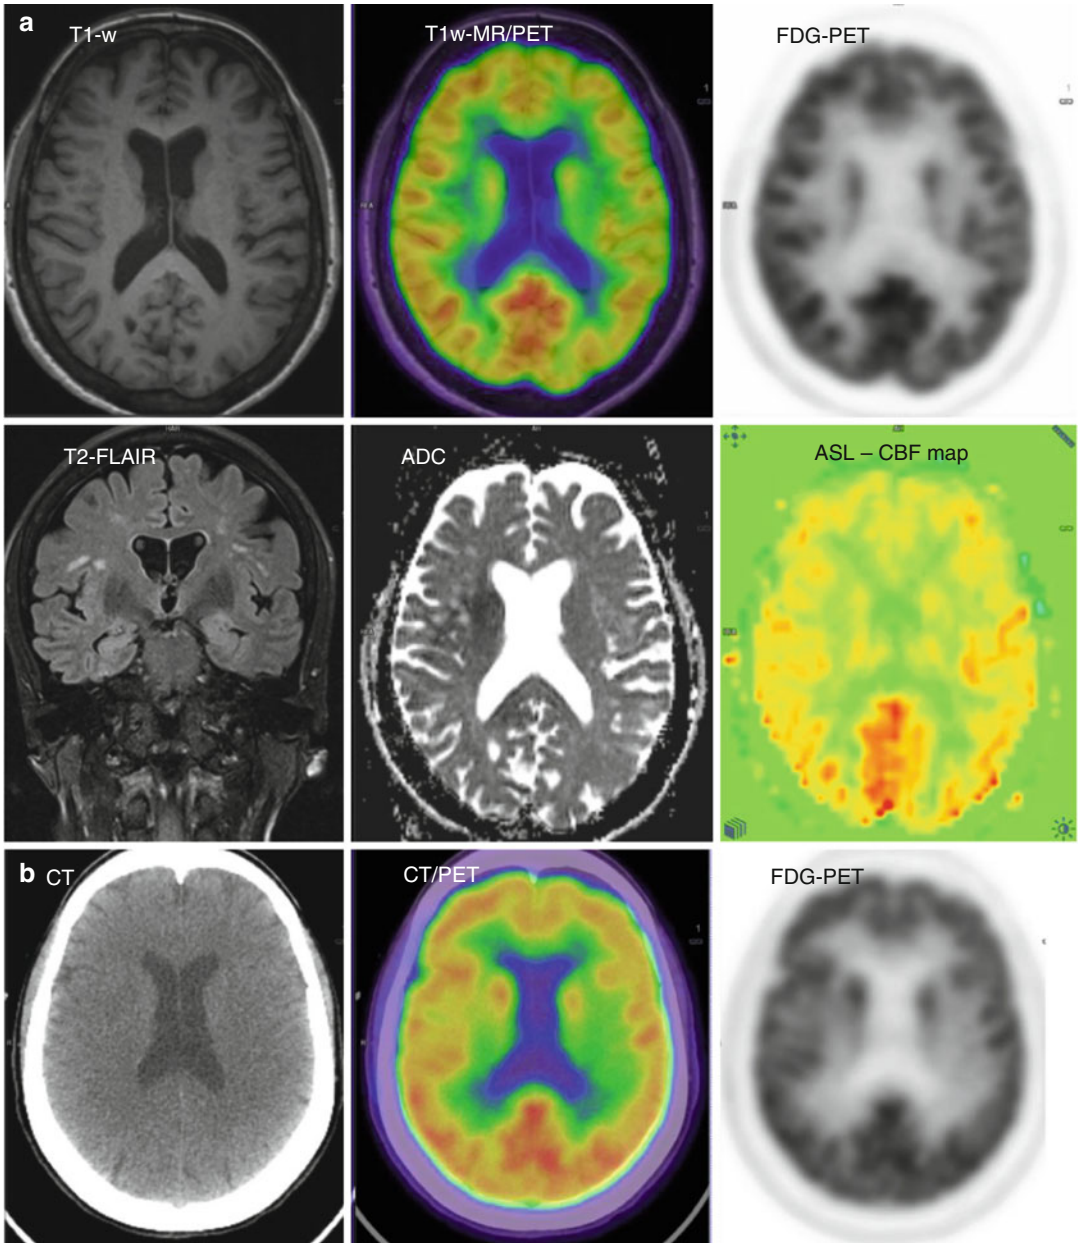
Vascular dementia: PET/MR (a) vs. PET/CT (b), male patient, 67 years old, MMSE 17, CDR 2, Hachinski Score 8. The Hachinski Ischemic Scale is a tool widely used to identify a likely vascular component once a dementia diagnosis has been established. It is not itself a validated
